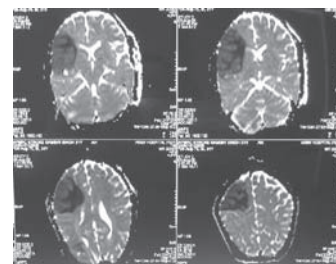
MRI showing infarct in the region of middle cerebral artery
